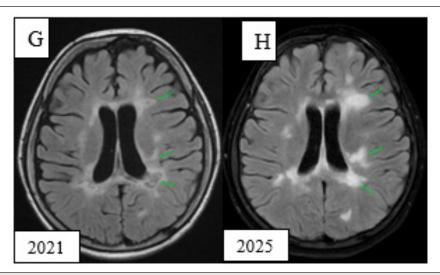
MRI Brain with contrast showed new contrast enhancing lesions (arrows) in periventricular white matter in (H) 2025 as compared to (G) in 2021 (Case 1).
